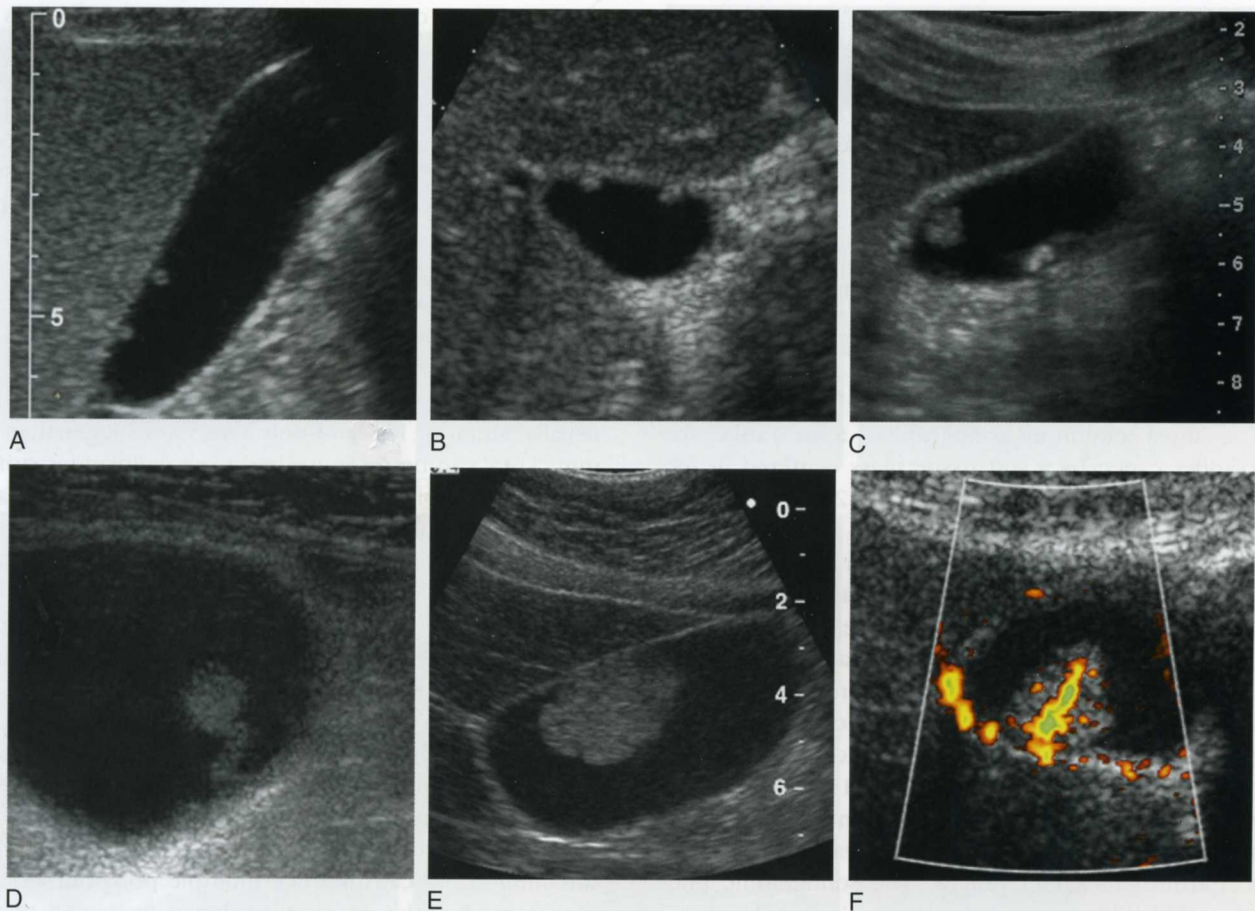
Gallbladder polyps in different patients. Longitudinal (A) and transverse (B) views show two small (<5 mm) non-shadowing polypoid defects along the non-dependent portion of the gallbladder typical of cholesterol polyps. C, Oblique view shows a stone in the dependent portion and a non-shadowing polypoid filling defect in the non-dependent portion. This is slightly larger than expected for a typical cholesterol polyp but demonstrates the typical “ball on the wall” sign. D, Unusual case showing the stalk of a cholesterol polyp. E, Three-centimeter polyp that was pathologically proven to represent an adenoma. F, Color Doppler view shows the vascular pedicle of a polyp, which helps to distinguish this from tumefactive sludge.
